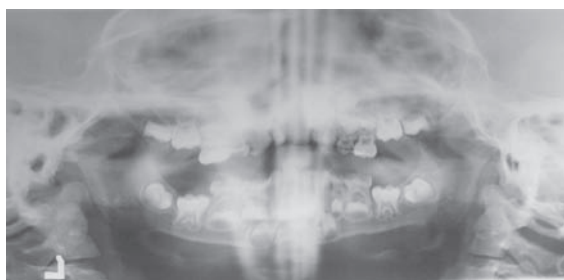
Panoramic mandibular X-ray demonstrated irregular and crowded teeth.
